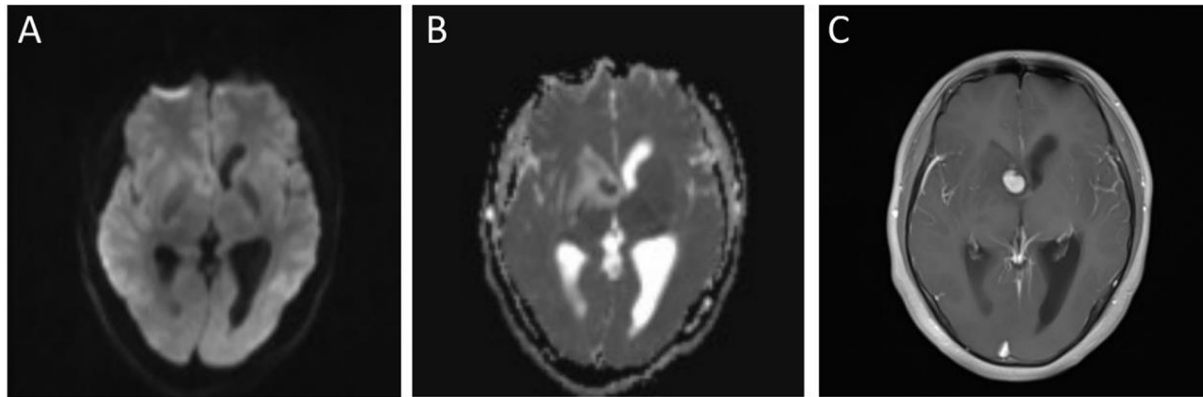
Case 3: MRI of primary central nervous system lymphoma A: Hyperintensity on DWI, B: Hypointensity on ADC, C: The lesion became more even with enhanced scanning, no gap shape was shown around enhanced region while the defect without enhancement appeared “notch sign”, large area of edema was found around the lesion and no enhancement was found in edema belt.
